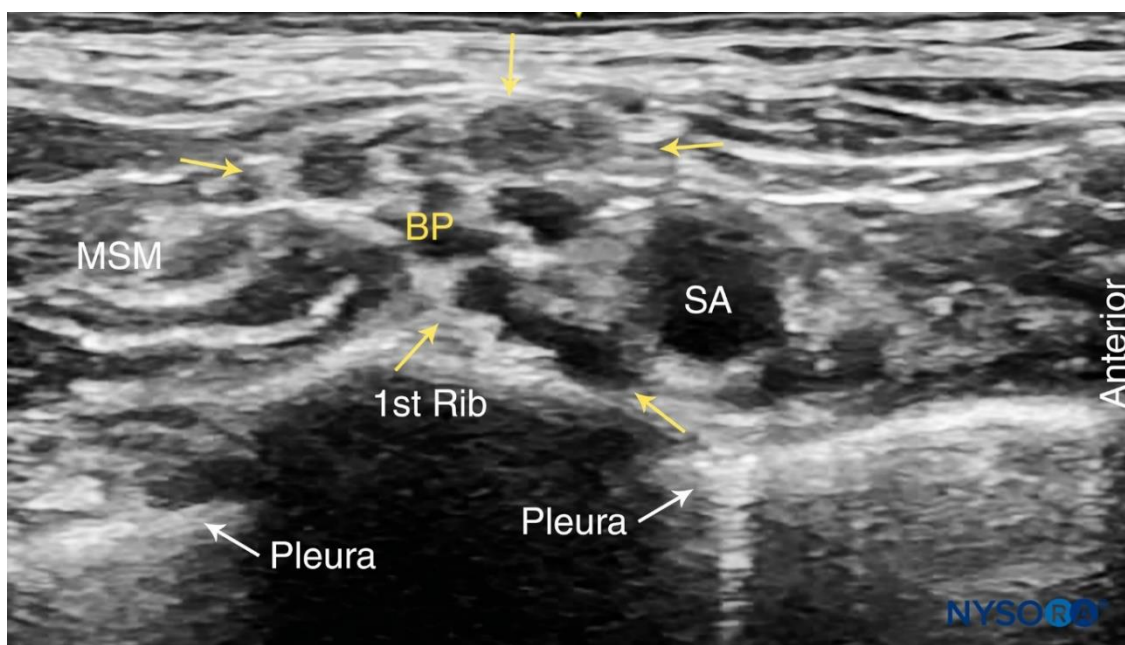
Ultrasound anatomy of supraclavicular brachial plexus. (MSM-middle scalene muscle, BP-brachial plexus, SA-subclavian artery)
